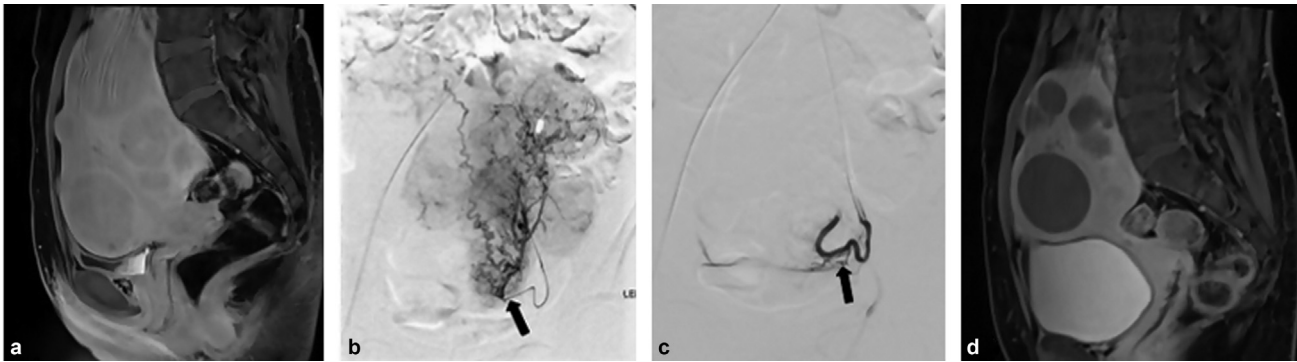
A 34-year-old woman presented with heavy and prolonged menstrual bleeding, pelvic pain, and pressure symptoms. She conducted her own research after being presented with only hysterectomy as a treatment option and came to our clinic seeking care. (a) Pre-UAE (uterine artery embolization) sagittal T1-weighted fat-saturated contrast-enhanced (CE) image shows multiple enhancing fibroids. (b) Preembolization digital subtraction angiography (DSA) of the left UA from the transverse UA segment (arrow) shows hypertrophic UA and opacification of multiple fibroids. (c) Postembolization left UA DSA shows occluded UA and patent cervico-vaginal branch (arrow). (d) Six-month follow-up CE MRI shows the decreased size of the uterus and no enhancement of the fibroids consistent with cystic degeneration. During the clinic follow-up, she expressed resolved heavy, prolonged bleeding and bulk symptoms.
